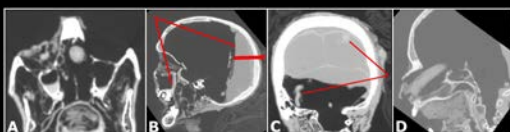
CT scan of Lady Hudson, showing (A) the damaged orbit and ethmoid air cells, (B) resin pooled in the posterior of the cranium and maxillary sinus (thin lines), a potential sphenoid fragment (thick line), (C) resin-impregnated linen rolls (indicated), and (D) the nasal tampon.
